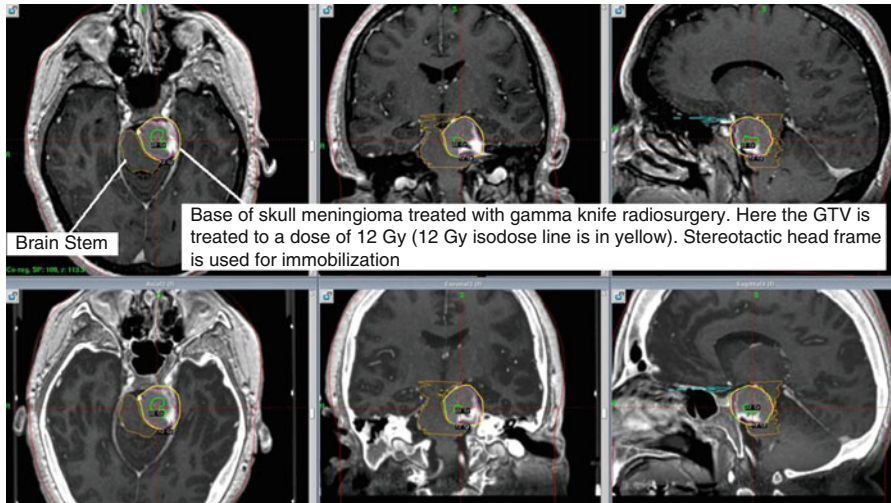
Base of skull meningioma shown in the axial, coronal, and sagittal plane treated with SRS (CT/MRI fusion); the 12 Gy isodose line is conformally covering the PTV
